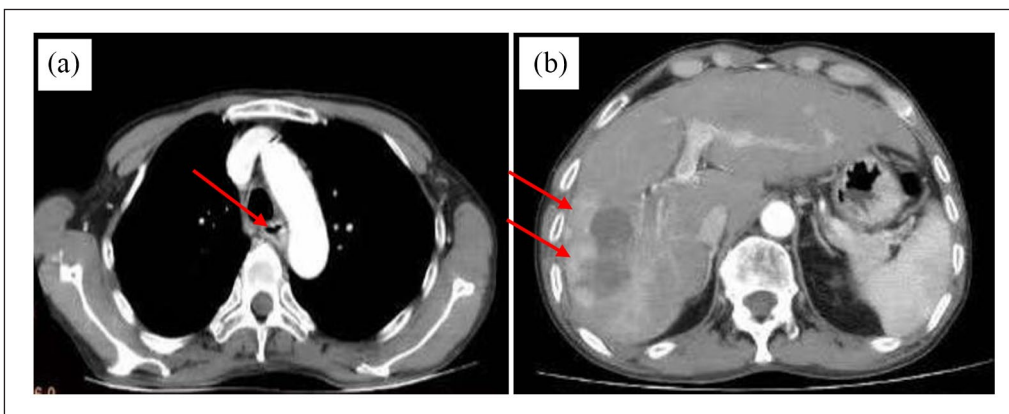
(a) The patient underwent a chest-enhanced CT examination after admission. (b) Results of upper abdominal enhanced CT examination. Based on the chest-enhanced CT examination, the patient has esophageal stenosis caused by the compression of the esophageal tumor.
